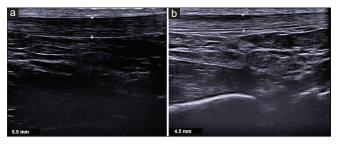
Sonographic images showing AT thickness in a DM patient (a) and a healthy volunteer (b). AT: Achilles tendon, DM: Diabetes mellitus
